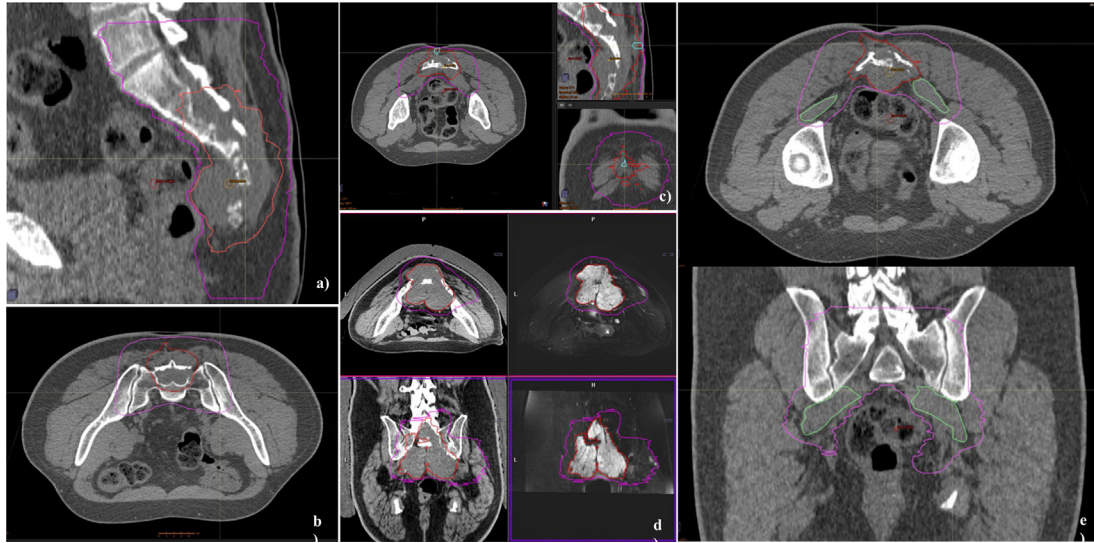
GTV and CTV contouring of sacral chordoma by CT/MRI scan a) one or two vertebral bodies rostral to the GTV and the whole sacrum caudally should be included b) sacroiliac joint contoured within the CTV c) biopsy tract or surgical scars should be included in the low-dose CTV d) the degree of lateral extension into the gluteal muscles is debatable albeit at least 1.5 cm margin of radiologically normal muscle should be included in the low dose CTV e) both piriform muscles should be entirely included in the CTV.
